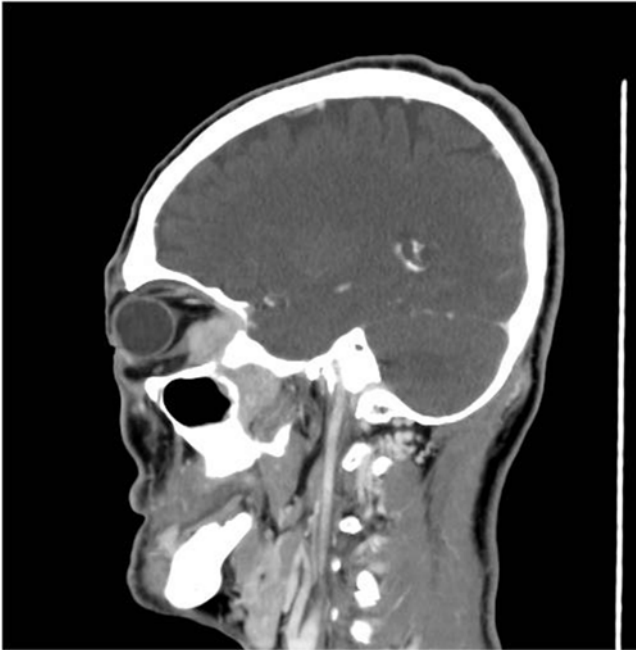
Computed tomography sagittal plane demonstrates a nasopharyngeal carcinoma invading the orbit posteriorly through the inferior orbital fissure (reprinted with kind permission from Springer Science+Business Media: *Ophthalmic Oncology*, Secondary Orbital Tumors Extending from Ocular or Periorbital Structures, 2011, p. 83, Roman Shinder and Bitu Esmali)
